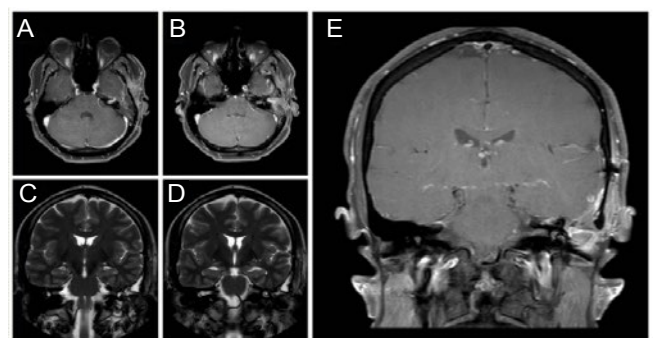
Post-operative MRI shows complete removal of the lesion.
